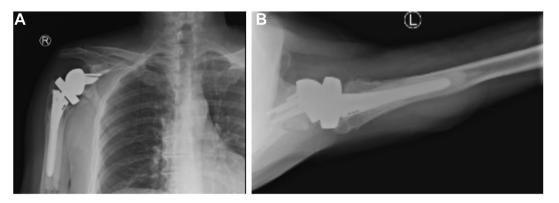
Postoperative x-rays at the 22-month follow-up. (A) An AP view of the right shoulder. (B) An axillary view of the right shoulder. AP, anterior posterior.
